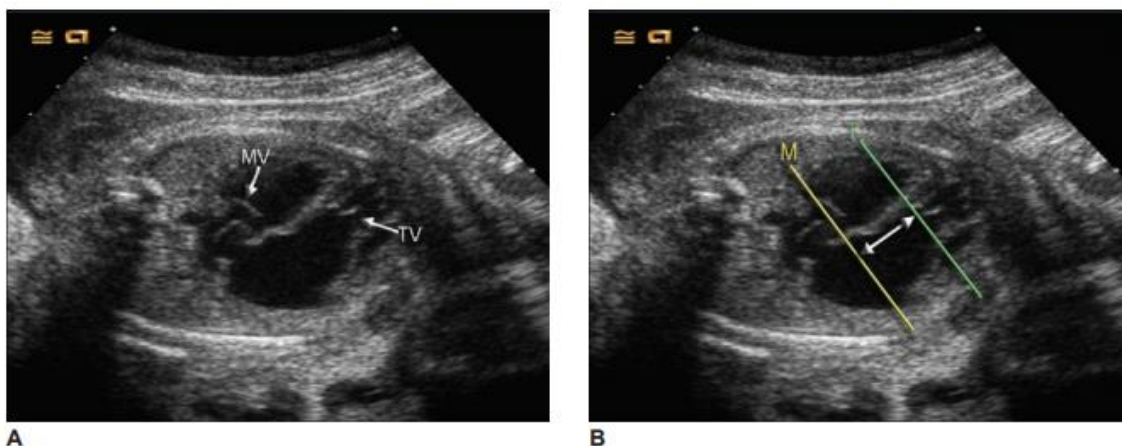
A: An apical four-chamber view showing mitral valve (M) and apically shifted tricuspid valve (T). B: Measuring the distance between the mitral and tricuspid valve indicates the severity of the inferior offset [12].
